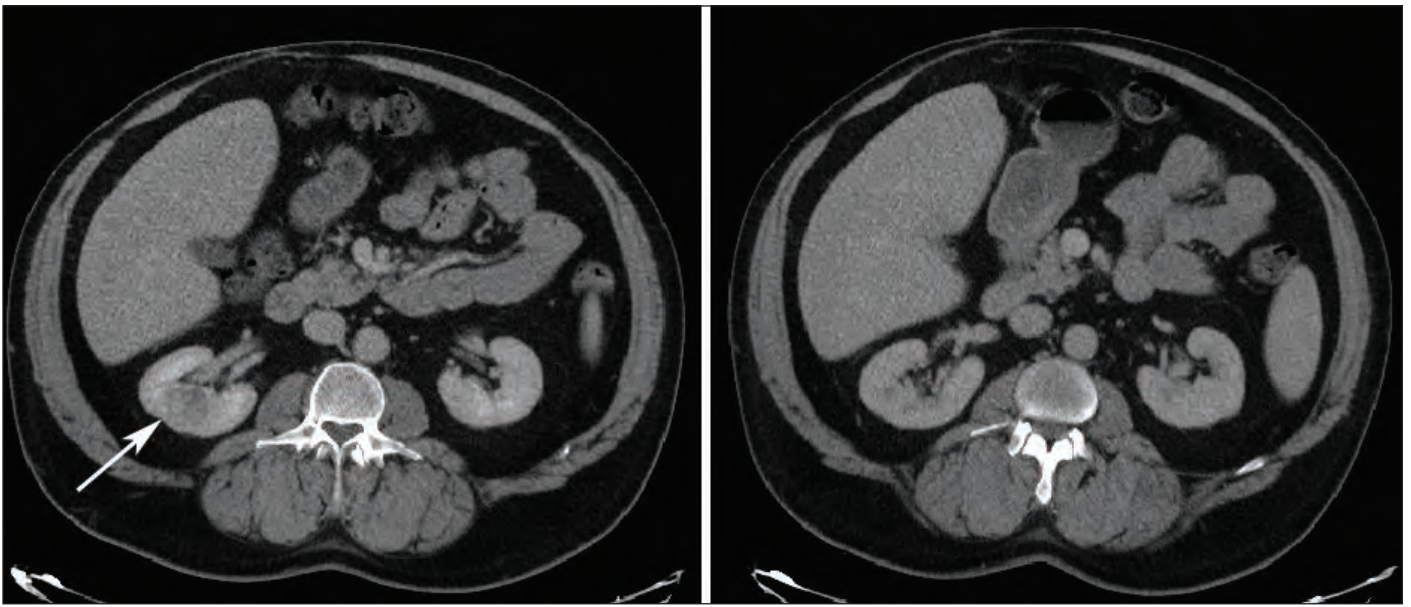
Enhanced abdominal computed tomography scan showing a 2.9 cm complex enhancing lesion (left; arrow), and complete resolution of this lesion 10 months later (right).
